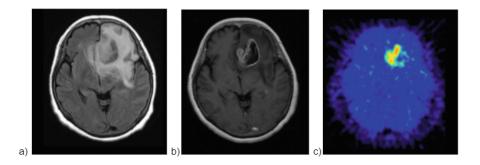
Glioblastoma imaged with different modalities. a) FLAIR MRI sequence. b) T1 weighted with gadolinium contrast. c) FMISO PET uptake in tumor.
